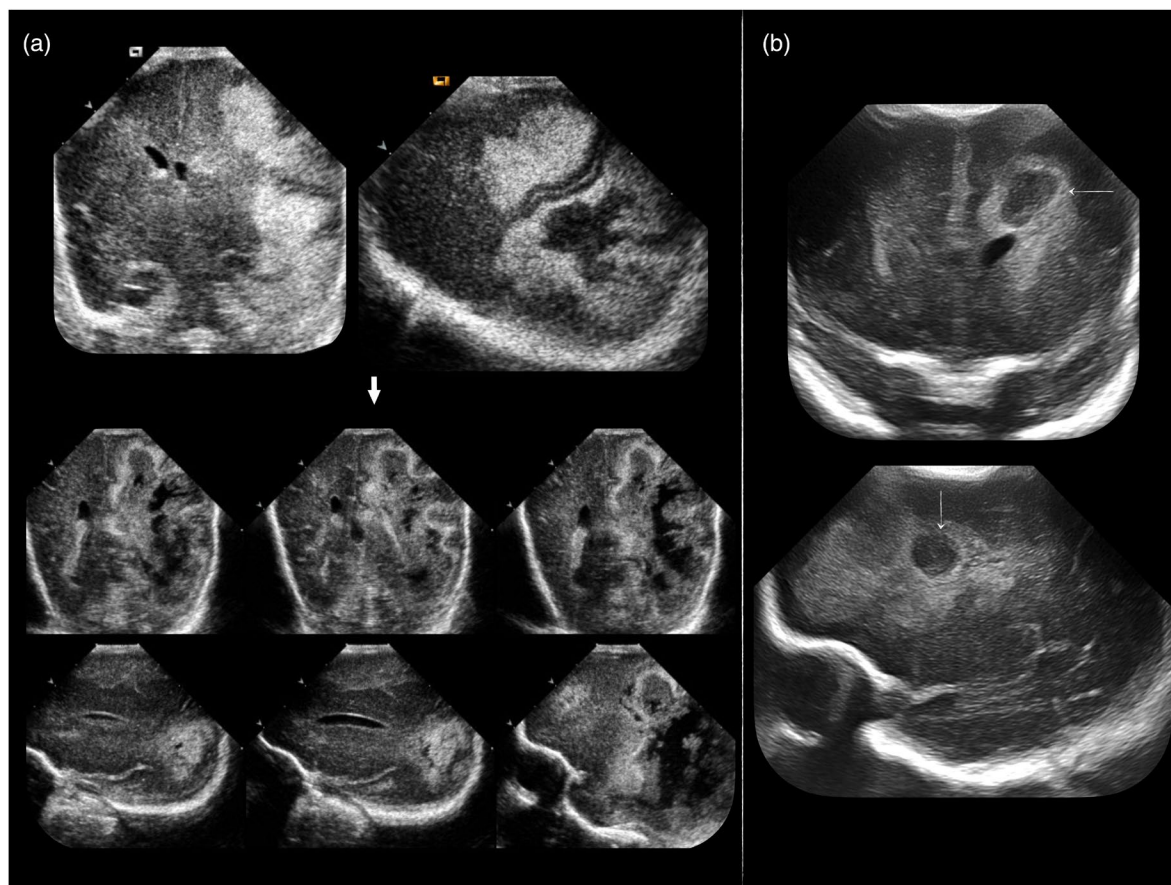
Bacillus cereus* meningo-encephalitis. (a) Infant born preterm (gestational age 30 weeks) with sepsis screen 48 hours before; lethargic, and full fontanelle but normal cerebrospinal fluid findings; cranial ultrasound shows predominantly unilateral extensive and irregular white matter echogenicity followed by destruction in the week after detection; the causative organism turned out to be *Bacillus cereus*. (b) Infant born preterm (33 weeks postmenstrual age) with *Bacillus cereus* in blood and cerebrospinal fluid: predominantly unilateral frontal white matter destruction.
